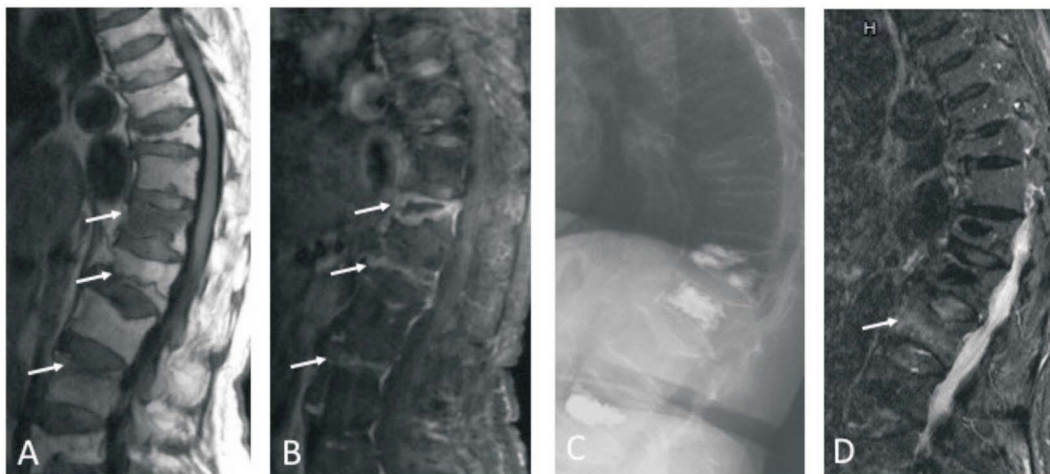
A 70-year-old female had a BMI of 22.1. She suffered from medical intractable back pain. (A) T1 weighted image MRI revealed bone marrow edema in T12, L3 and a cleft in L1 (arrows), another 5 old fractures were noted also. (B) A contrast enhanced MRI revealed new fracture in T12, L1 and L3 (arrows). (C) She underwent 3 segments percutaneous balloon kyphoplasty. (D) Back pain occurred 1 months later and a follow-up MRI revealed bone marrow edema in L2 (arrow), which indicated adjacent segment fracture.
